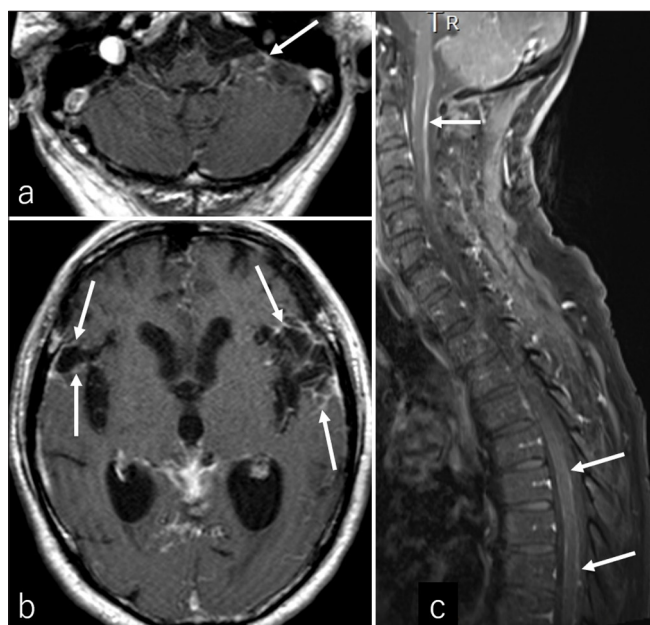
Postcontrast (a and b) axial and (c) coronal magnetic resonance images showing rim-like leptomeningeal enhancements along the cerebral cisterns and spinal cord (arrows).
